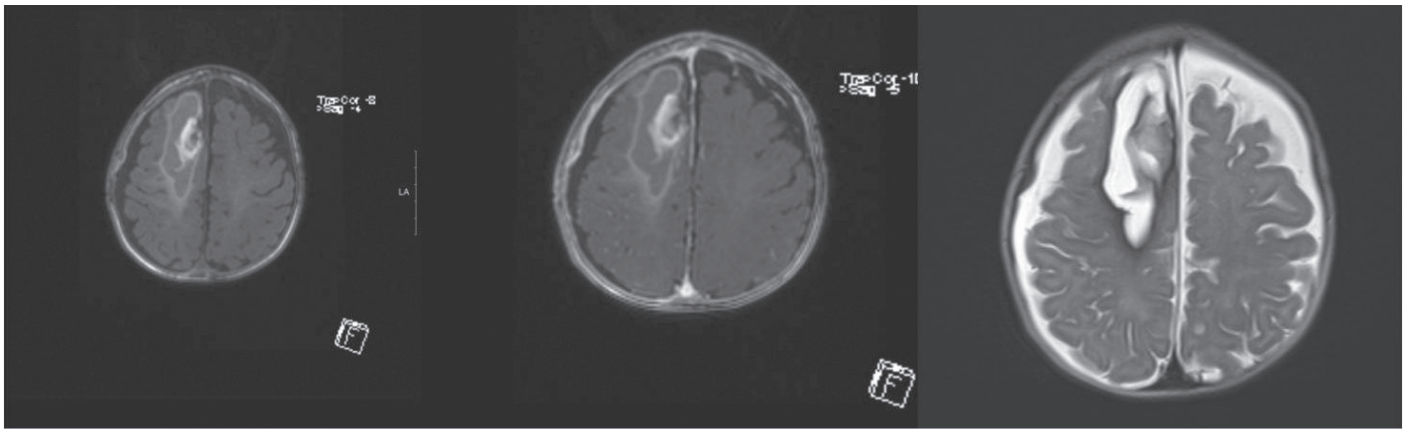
Cranial MR T1-weighted contrasted and non-contrast, T2 –weighted images of the patient.
